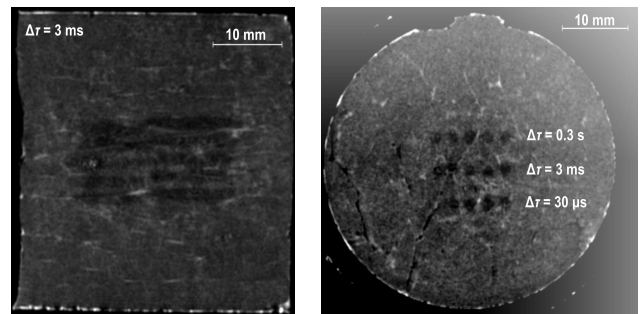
T1-weighted MR images of the axial (left) and radial (right) – in the focal plane – cross-sections of the necrotic lesions formed inside the tissue after its repeated 3 s exposure on both sides to 5 HIFU beams with a 1.08 MHz frequency, 0.6 duty-cycle and varied pulse duration: 30 μ s (bottom); 3 ms (center); 0.3 s (top).
